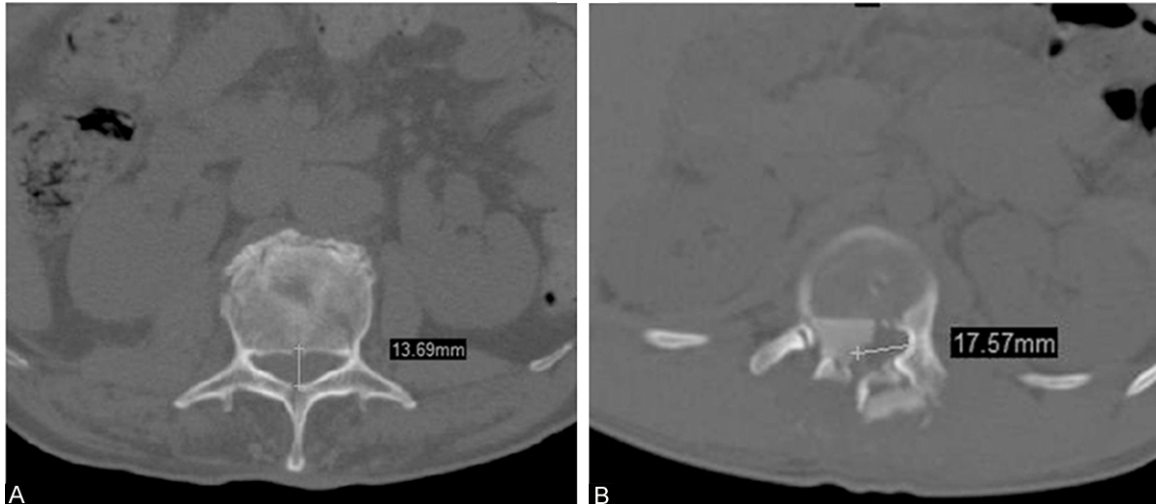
The axial CT images for mid-sagittal diameter and transverse canal diameter. A. The Mid-sagittal diameter was 13.69 on the axial CT image. B. The transverse canal diameter was 17.57 mm on the axial CT image.
